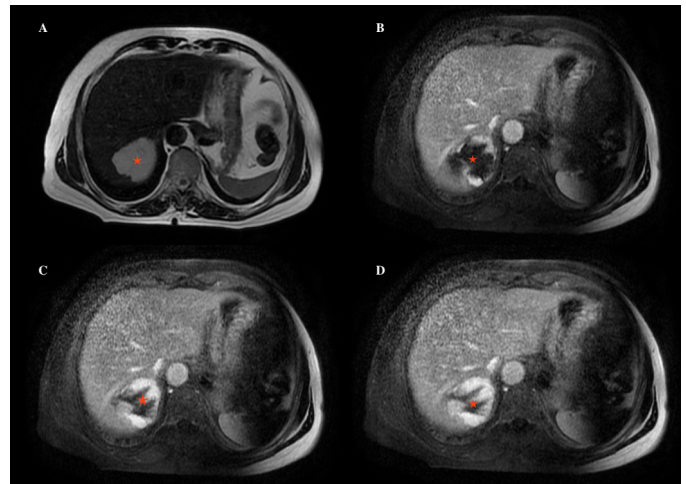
Contrast-enhanced dynamic MRI of the liver in a patient with a right-lobar hepatic hemangioma. A) On the precontrast T2-weighted image, a hyperintense lesion is observed in the right hepatic lobe (marked with a red star). (B–D) Dynamic postcontrast images demonstrate progressive, discontinuous centripetal enhancement, which is characteristic of hepatic hemangioma.
